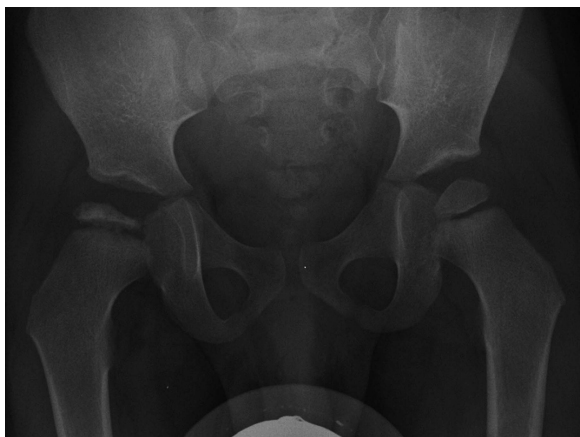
Radiograph of the pelvis 6 months after onset of symptoms.
